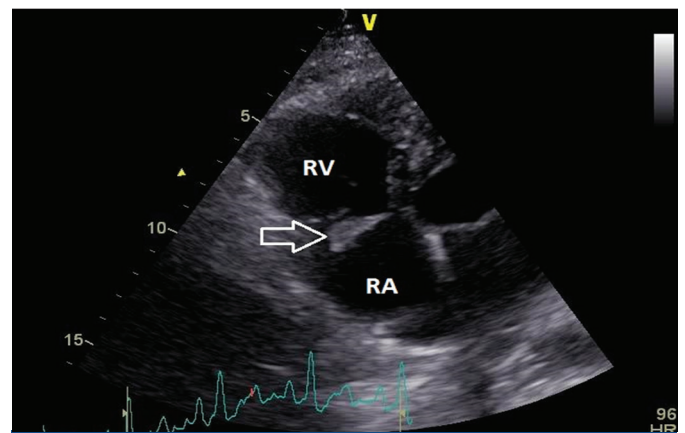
Transthoracic ultrasonography showing a large vegetation on the septal leaflet of the tricuspid valve.
